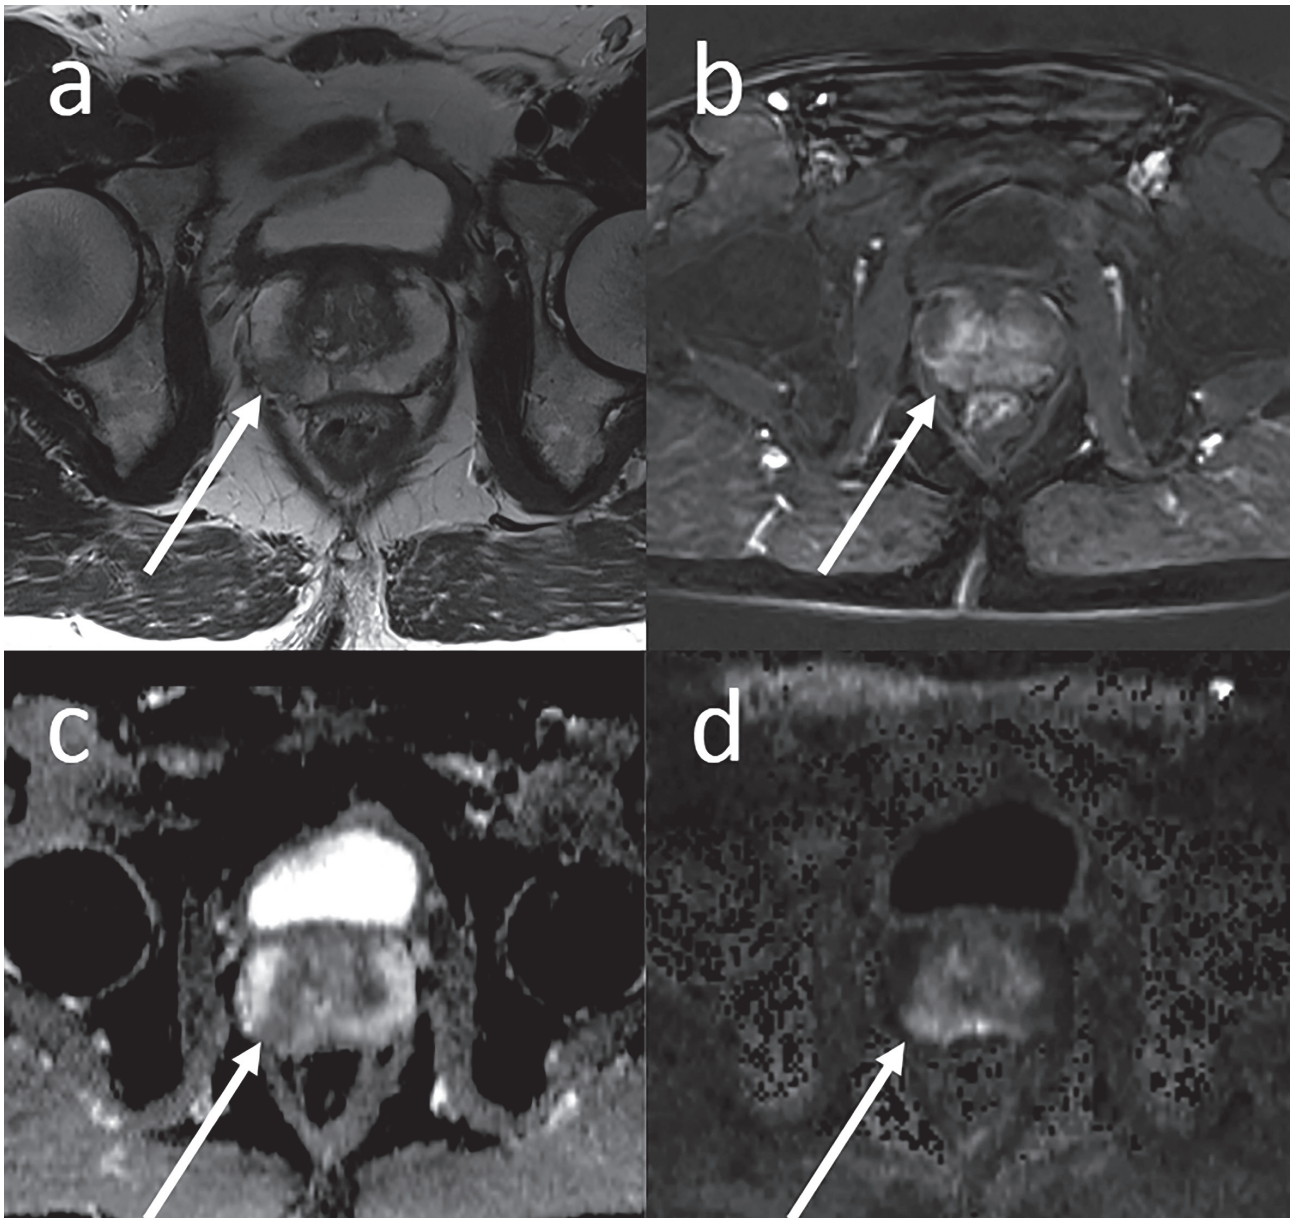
Multiparametric MRI of a focal prostate carcinoma in the right peripheral zone of the mid prostate.
